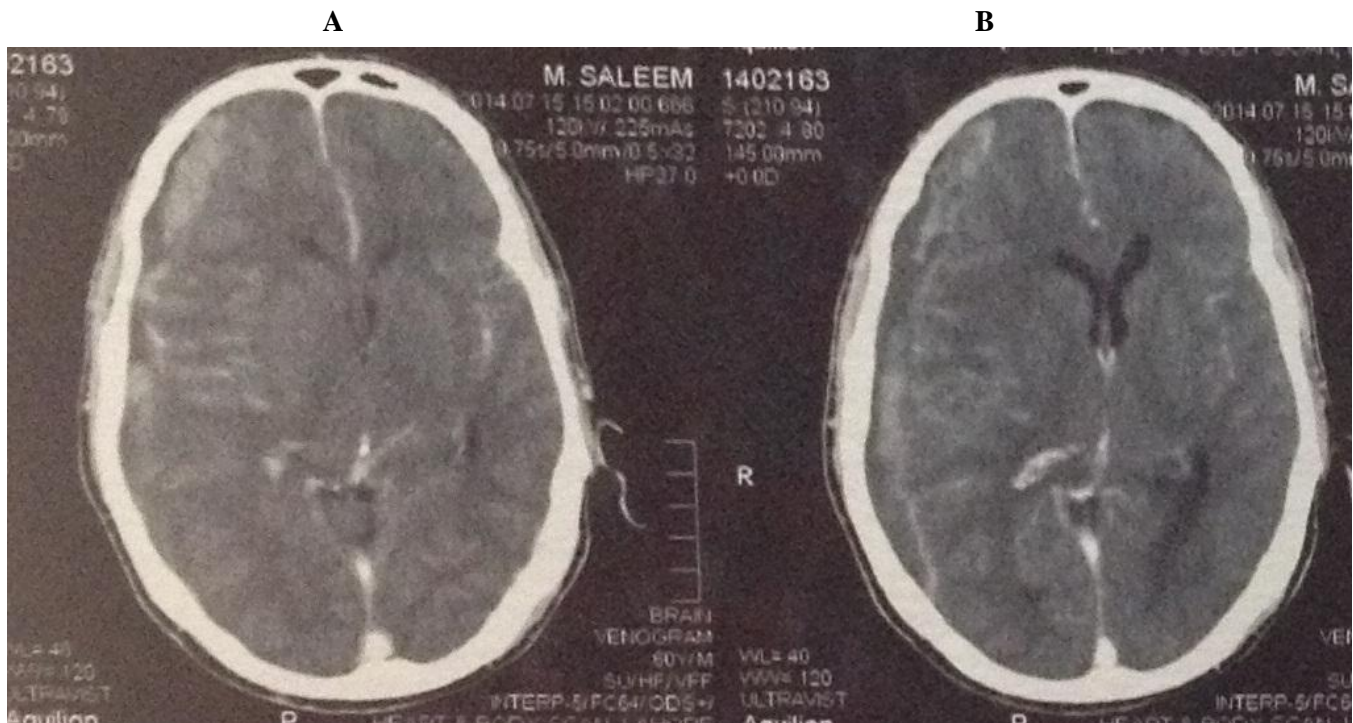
CT Scan of brain showing right frontoparietal chronic sub duralhematoma with midline shift.
